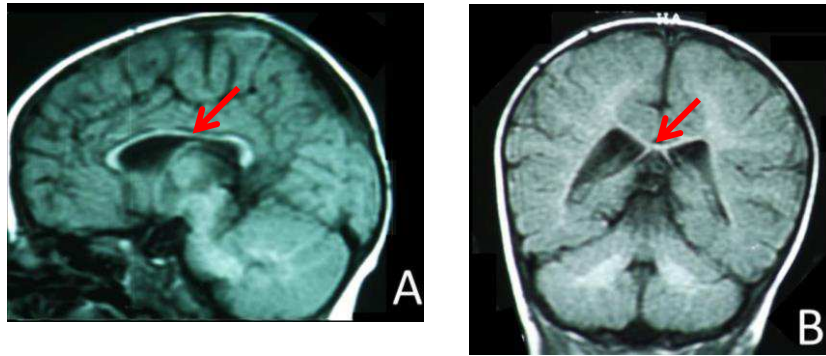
Brain MRI of the younger sibling of Family 8 at 8 months of age. The images show slight thinning of the corpus callosum in sagittal (A) and coronal (B) view (red arrow).
